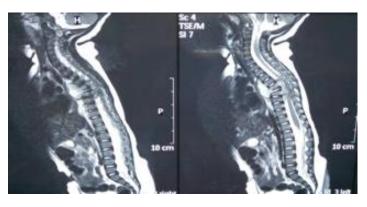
Sagittal view of MRI Spine T2 weighted.
